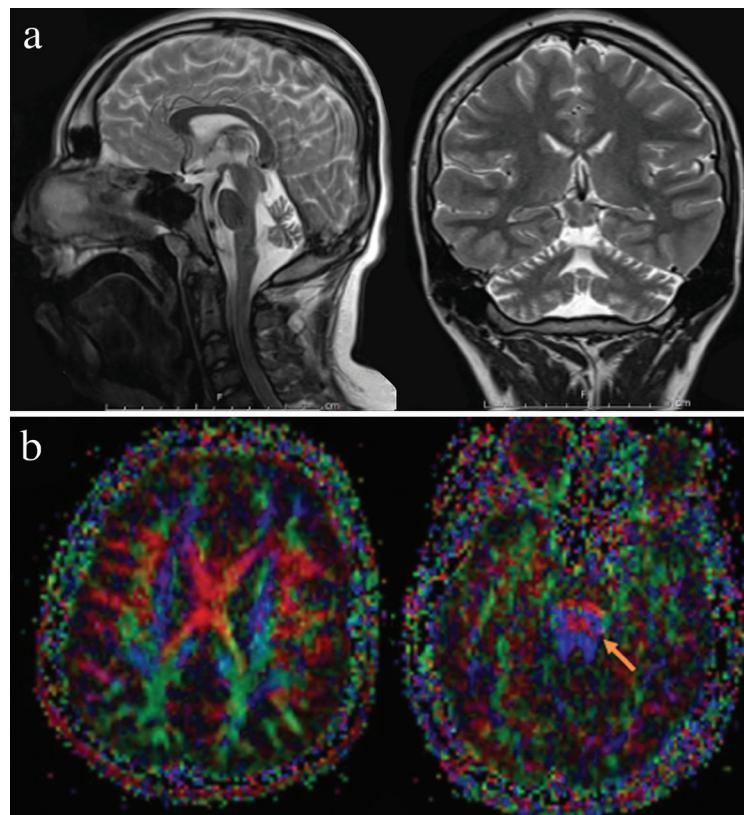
a, b. Sagittal and coronal brain magnetic resonance images of a 14-year-old boy revealed cerebellar vermic volume loss with normal pons and spinal canal (a). Diffusion tensor imaging displayed thinning of the tegmental extending through corticospinal tracts (b).
